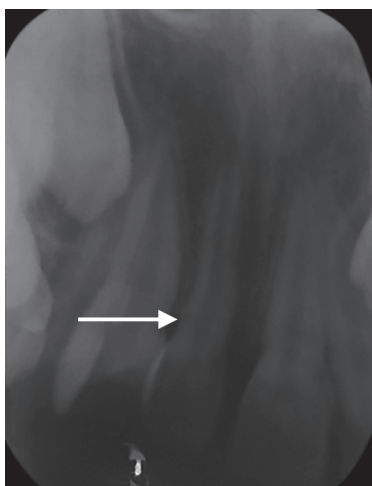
Intraoral periapical radiograph showing mesiodens
